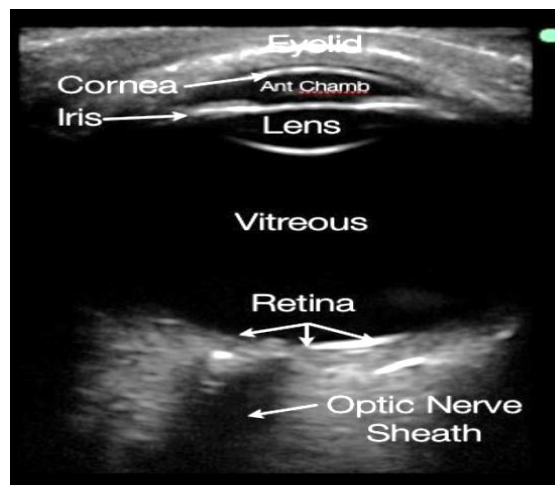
Normal Ultrasonography vitreous cavity, concave retinochoroidal layer and the optic nerve show (Sankara Nethralaya ... et al 2006)
